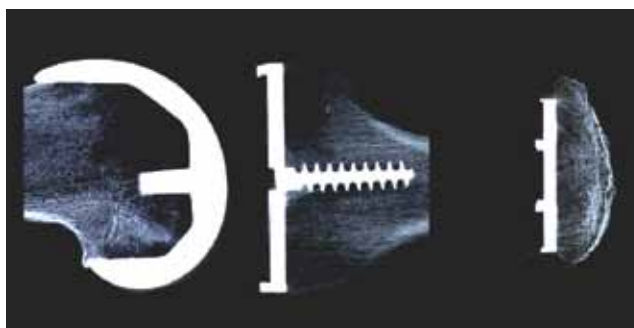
High-resolution contact radiographs of 3-mm-thick sections of all femoral, tibial, and patellar components from 24-year retrieval.
